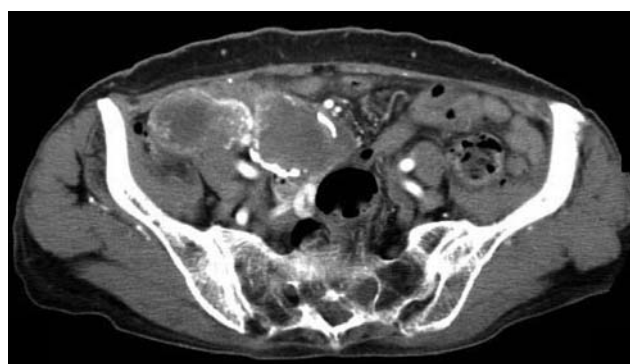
Computed tomographic image of the abdomen, showing solid and peripheral enhanced tumors with calcification in the right lower abdomen.
